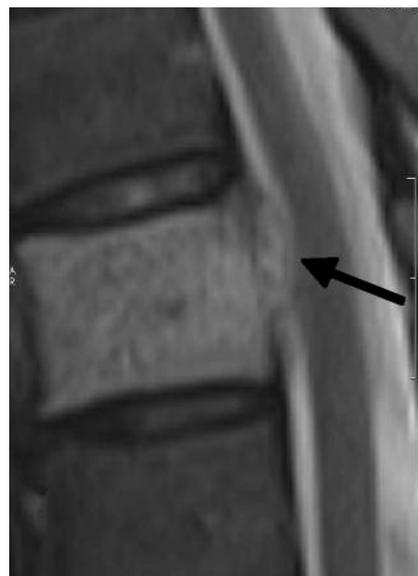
Sagittal T2-weighted MR image. (enlarged view). Obvious destruction of the posterior vertebral wall, towards epidural space (black arrow).
